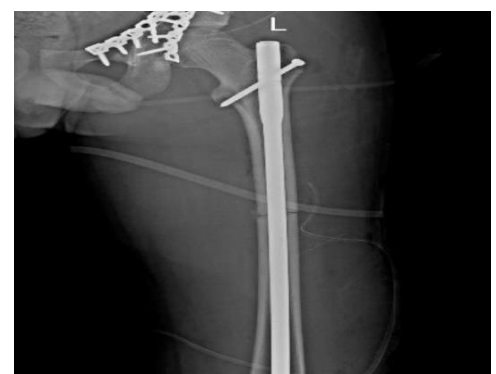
Postoperative anteroposterior (AP) radiograph of the femur
